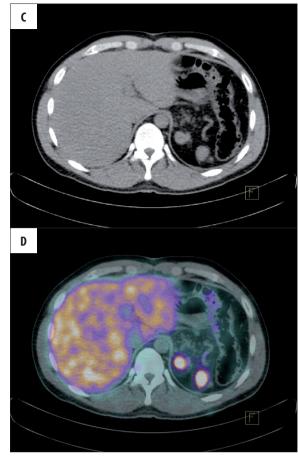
Patient K.A.: CT scan and PET-CT with gallium-68 labeled somatostatin analogues on 25 May 2009: two oval masses in the left upper abdomen, not vizualised before, initially interpreted as cancer localizations.
